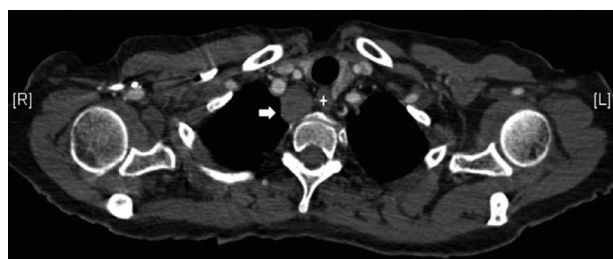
Thoracic computed tomography (CT) with intravascular contrast showing homogeneous mass in right superior mediastinum (white arrow), distinct from esophagus (+) with homogeneous enhancement.
